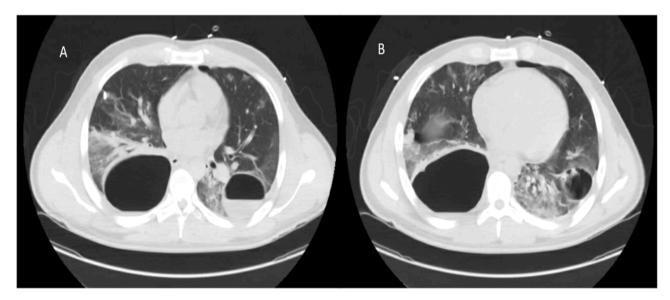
A: Chest CT following right chest tube placement showing decompression of the pleura with large posterior fluid containing bulla. Fig. 2B: Chest CT showing left sided fluid containing bullae along the major fissure with small pneumothorax
